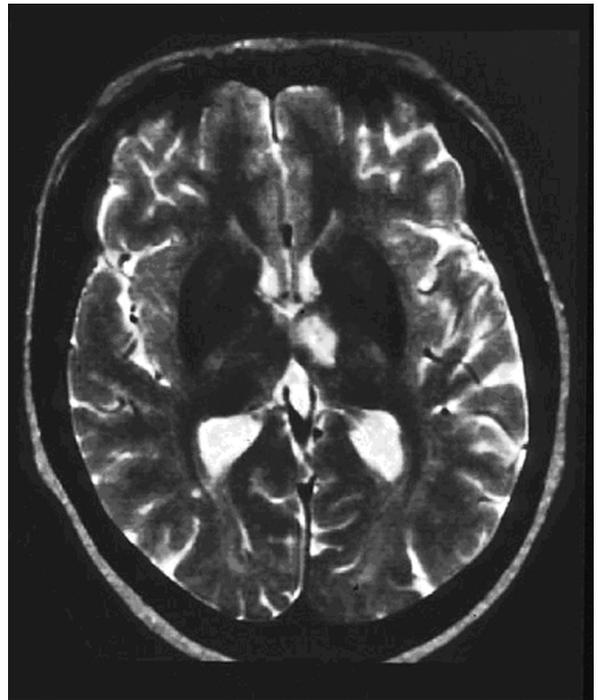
Left tuberothalamic territory infarction (MRI T2-weighted imaging).
